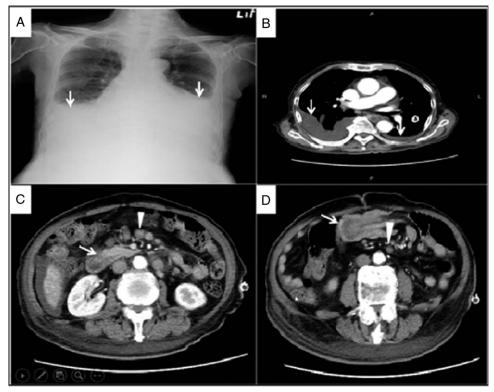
Chest X-ray shows bilateral pleural effusions (A, white arrow). Chest CT scan exhibits bilateral pleural effusions (B, white arrow). Representative photographs of the CT scan of abdomen and pelvis indicate two segments of small bowel intussusception (C, D, white arrow), and one presents an abnormal enhancement of the leading point with enlarged regional small lymph nodes (C, D, white arrowhead). CT, computed tomography.
